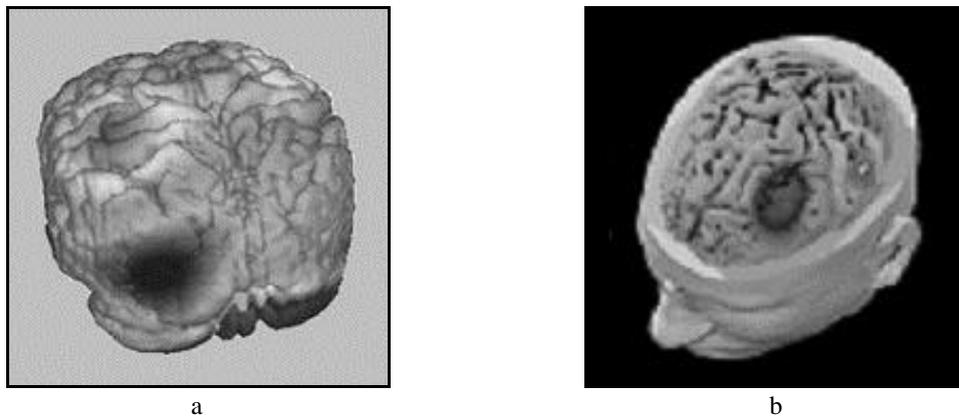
a: EEG data registered with the MRI image. b: SEP data (Sensory Evoked Potentials) registered with the MRI image. In the original colour image the hue was proportional to the electric potential (courtesy: authors of [17]).
